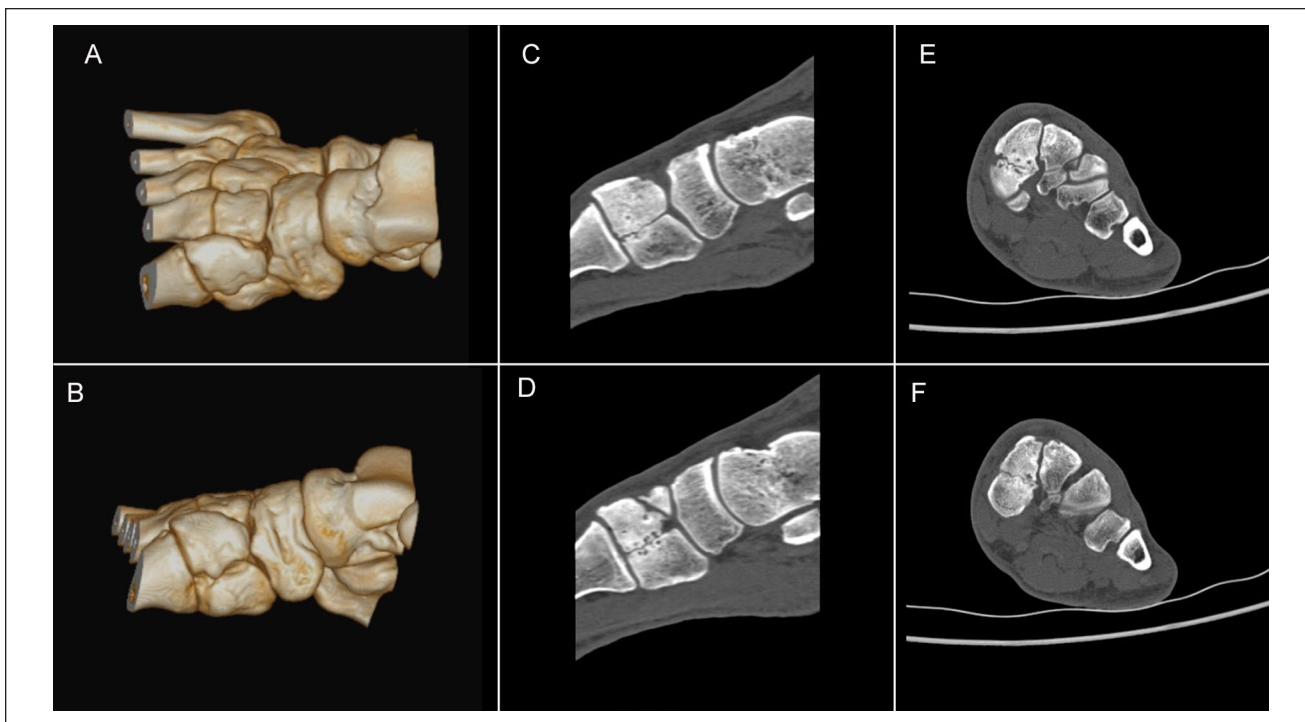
Computed tomography scan showing (A, B) bipartition of the medial cuneiform on 3D reconstruction. (C, D) Increased sclerosis and subchondral cysts in the area of the pseudoarticulation can be seen on sagittal slices. (E, F) Coronal scans reveal complete bipartition of the medial cuneiform.
